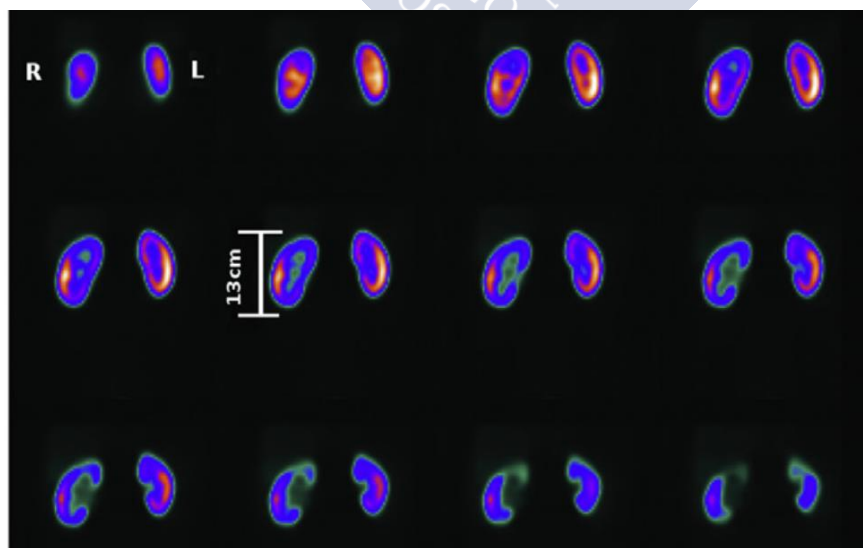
Coronal slices of a $^{99\text{m}}\text{Tc}$ -DMSA SPECT image showing the radiotracer uptake on the renal cortex. Image reproduced from Silva-Rodríguez et al. (2015).
